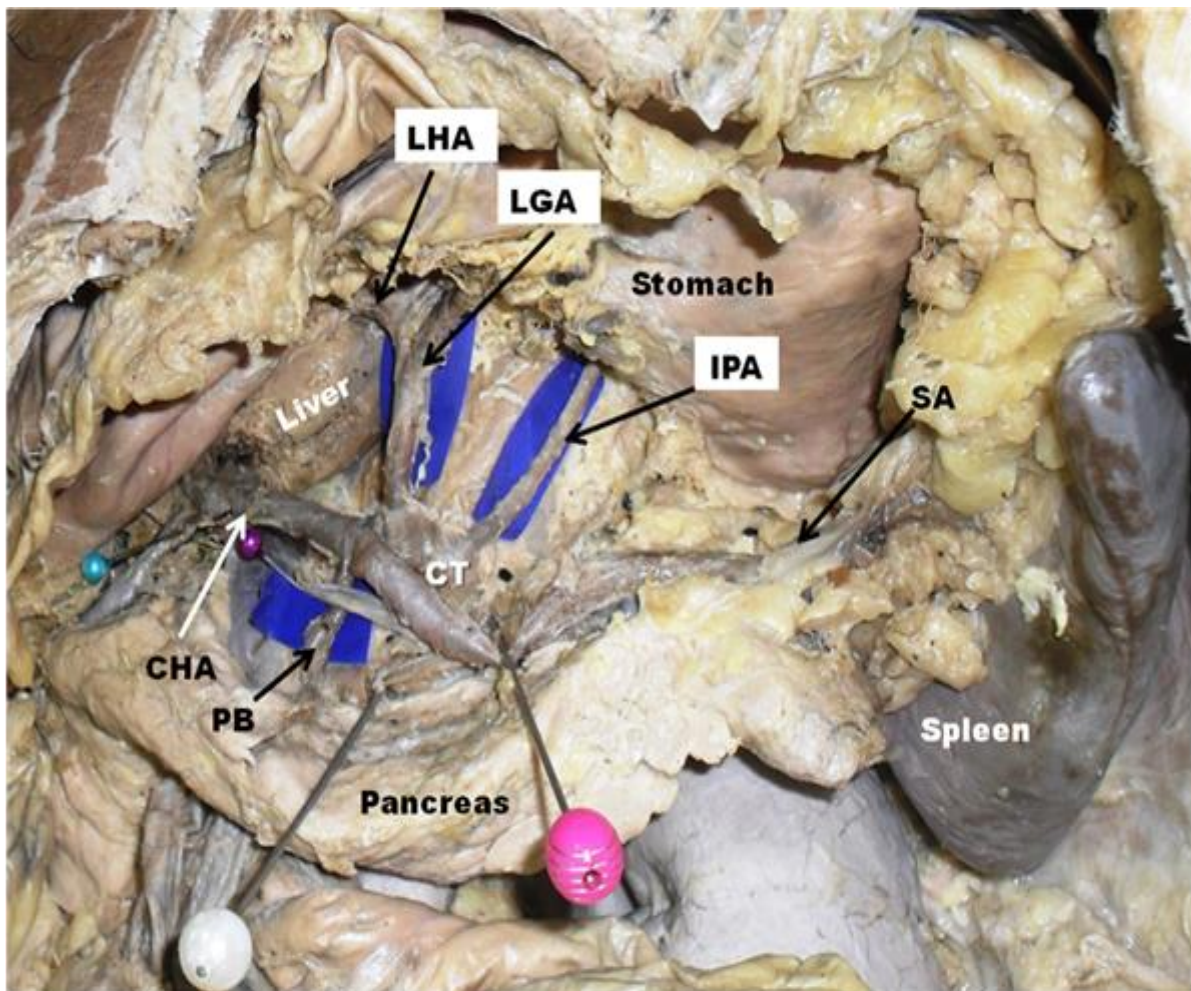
Dissection of abdomen showing the coeliac trunk (CT) with common hepatic artery (CHA), splenic artery (SA) and left gastric artery (LGA). Inferior phrenic artery (IPA) can be seen emerging from the proximal part of the coeliac trunk. PB-Pancreatic branch, LHA-Left hepatic artery.
